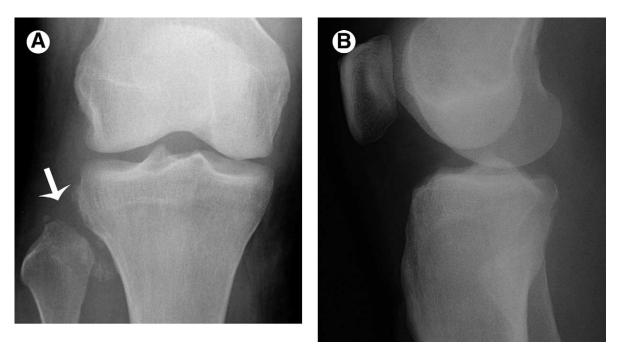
(A, B) AP and lateral radiographs reveal dislocation of the proximal tibiofibular joint. The joint space is clearly widened on the anterior view (arrow) and numerous tiny fragments are seen from the capsular avulsion. Associated mid tibial and distal fibular fractures are not shown. (Case is courtesy of Dr. Liem T. Bui-Mansfield, Brooke Army Medical Center, San Antonio, TX.)
